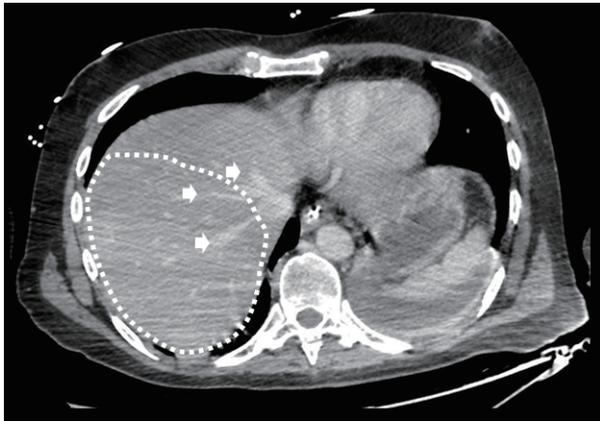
Computed tomography revealed that hepatic veins were patent and continuous after subtotal colectomy (white stars indicate the hepatic veins). The right liver, invisible on preoperative computed tomography becomes visible following decompression (white small lines).
